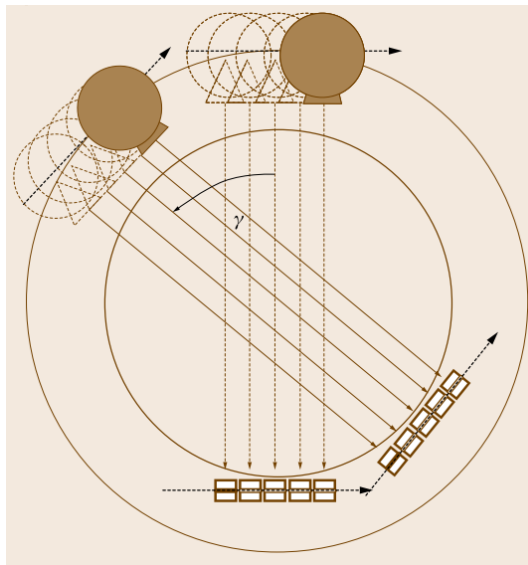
First generation of CT devices, equipped with a beam emitter and a single receptor. This are moved linearly, and the configuration is rotated through different projection angles  $\gamma$  [6].
